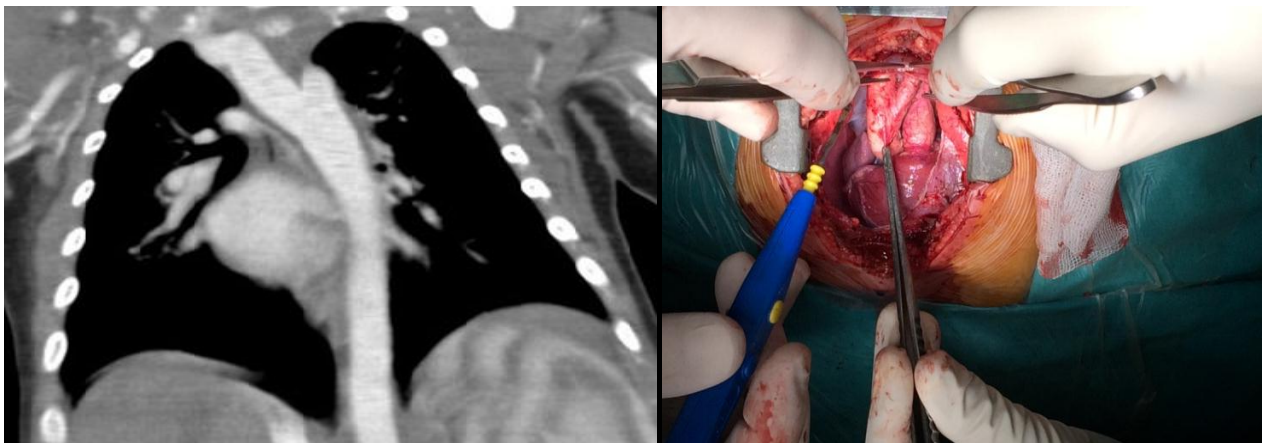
Aberrant right subclavian artery was detected in CT angiography.
